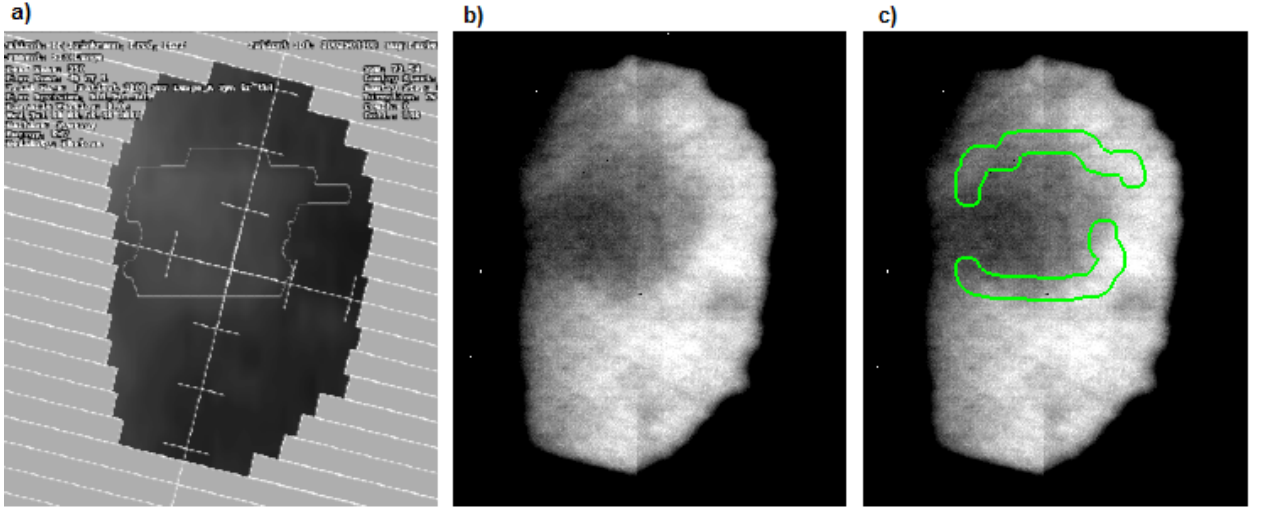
a) Digitally reconstructed radiograph (DRR) showing the tumour and CTV. (b) Representative portal in corresponding phase of breathing relative to DRR, and (c) definition of reference mask based on macroscopic tumour contour defined on DRR.*
